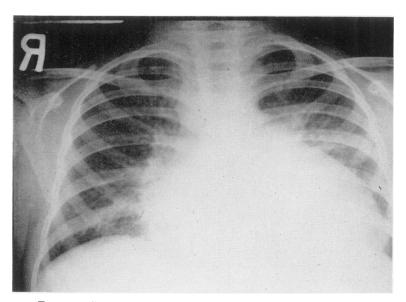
Case 2. X-ray of the chest taken shortly before death. Marked cardiac enlargement and pulmonary congestion. Some of the increase in the size of the cardiac silhouette may have been due to pericardial fluid.
